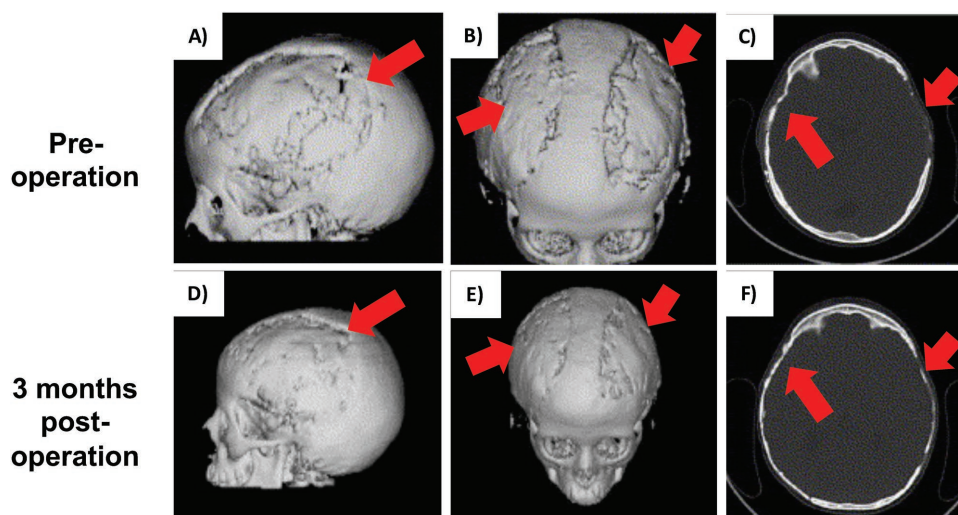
A seven-year-old girl suffering from closed multi-fragmental craniofacial fractures was treated with autologous ASCs combined with autologous fibrin glue extracted from plasma, and processed using the CryoSeal FS System. A) Axial view, left side; B) axial view, top; and C) axial cross-section CT scans of widespread calvarial bone defects preoperatively. D–F) CT scan of the same patient three months postoperatively showing improved healing in the treated regions. Red arrows indicate the main craniofacial defects. Reproduced with permission.^[106] Copyright 2004, Elsevier.
